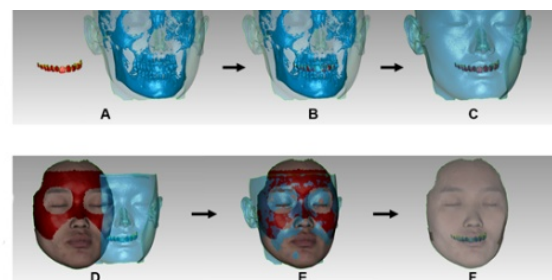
CBCT-based dentofacial image superimposition. Image registration of dental model into CBCT image. Registration of two sets of dentofacial models obtained from CBCT and 3D facial imaging
